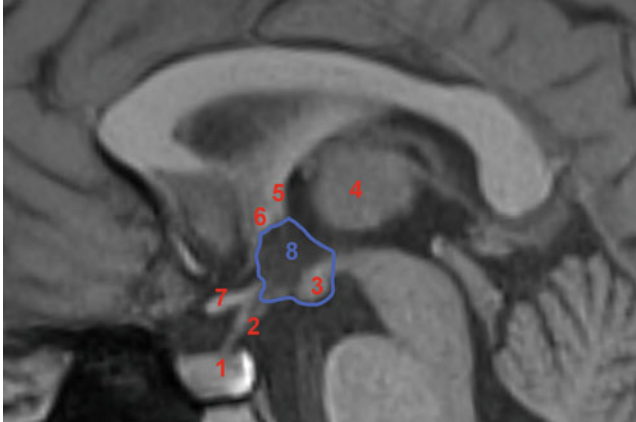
Sagittal section of a T1-weighted MRI of the diencephalon. The outline of the hypothalamus is depicted in blue. 1: Pituitary gland (the posterior pituitary shows a characteristic bright signal); 2: Pituitary stalk; 3: Mammillary body; 4: Thalamus; 5: Fornix; 6: Anterior Commissure; 7: Optic Tract; 8: Hypothalamus
